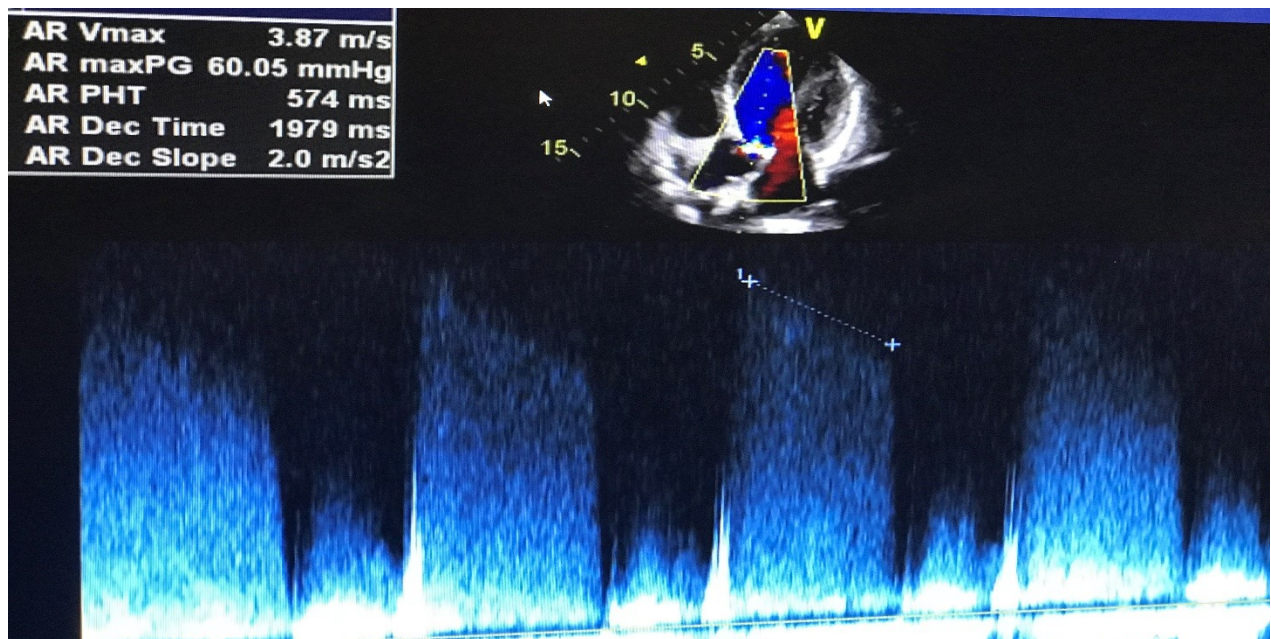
Transthoracic echocardiography (TTE) showed left ventricular systolic dysfunction with ejection fraction of (40-45%) grad two diastolic filling pattern with elevated left ventricle pressure, moderate-to-severe aortic regurgitation, moderate aortic stenosis, bicuspid aortic valve with thickening and calcification compatible with vegetation
